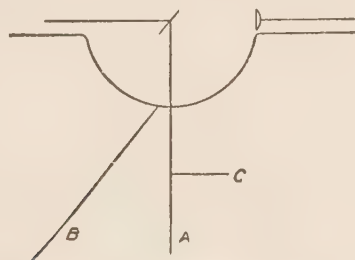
Above figure shows the three sources of rays from an X-ray tube. "A" represents the principal ray, which is generated at the target. "B" represents the wild X-ray, generated from the walls of the tube. "C" represents the secondary ray, which is generated whenever the principal or wild ray strikes an object. Rays "A" and "B" vary with the resistance of the tube. Ray "C" varies with the density of the substance struck by principal ray. "B" rays are generated from the entire hemisphere of the tube in front of the target.
